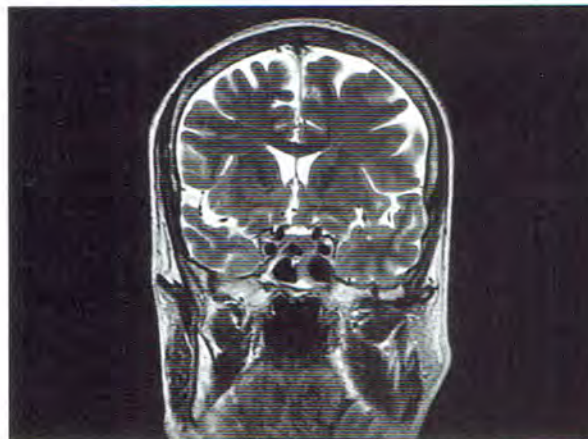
A magnetic resonance imaging was also acquired for anatomic characterization. It demonstrated an atrophic right hippocampus with abnormally high T2-weighted signal compatible with medial temporal sclerosis.
